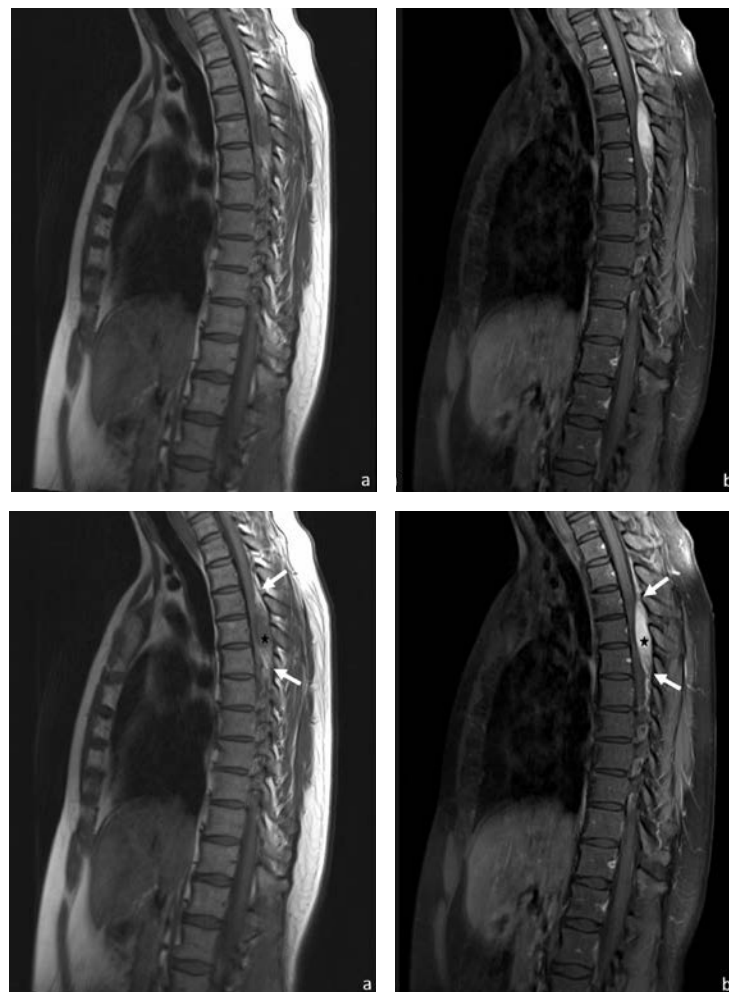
Sagittal T1-weighted pre-contrast without fat suppression (a) and corresponding sagittal T1-weighted fat suppressed post-contrast (b) images.
